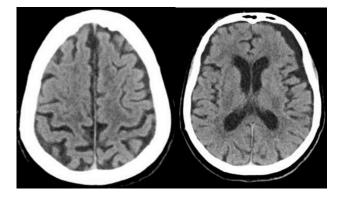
Follow-up CT scans of the head (axial scans): small residual bilateral subdural hygromas resorbed subdural hematomas Slika 3. Praćenje CT-a glave (aksijalne snimke): mali rezidualni bilateralni subduralni higromi resorbirani subduralni hematomi
